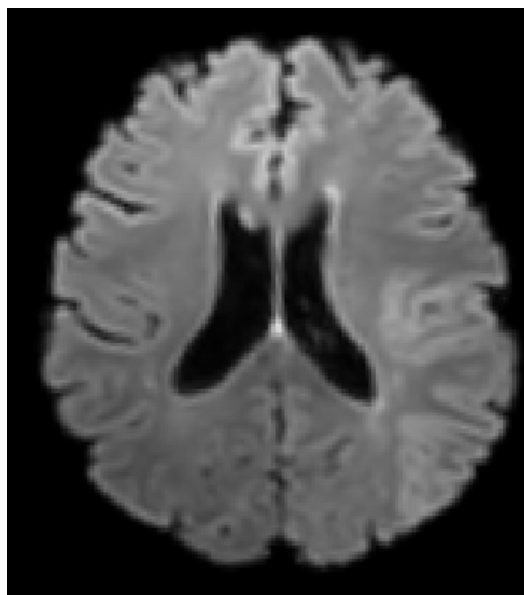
Example of a T₂ weighted FLAIR image from an acute ischaemic stroke patient.
